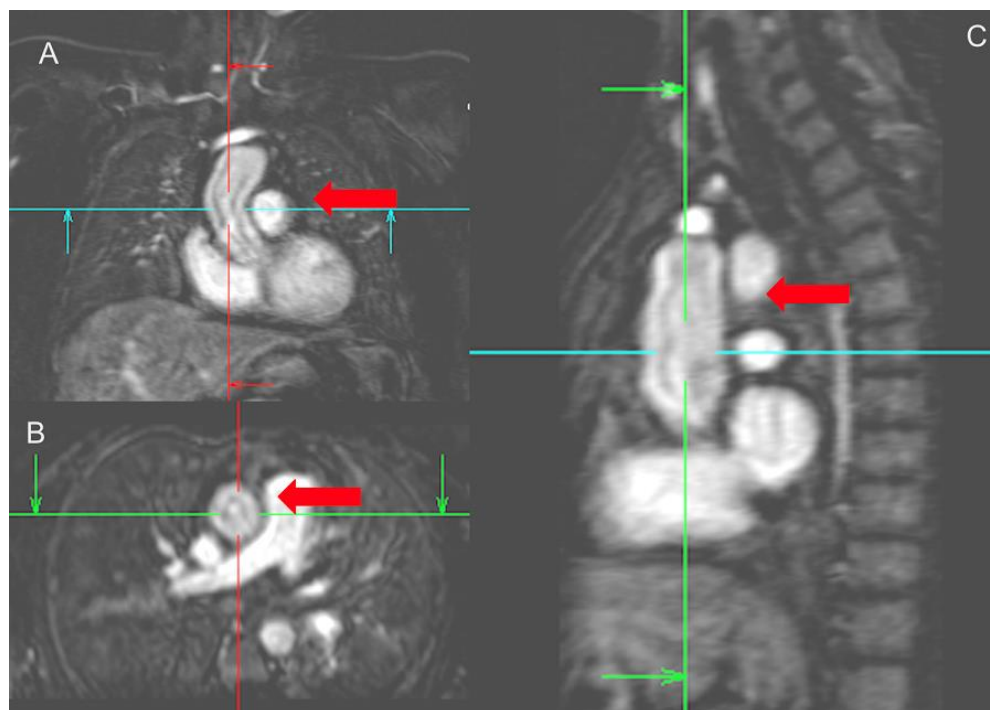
Cardiac MRI study where the recurrent Kommerell's diverticulum was first seen
